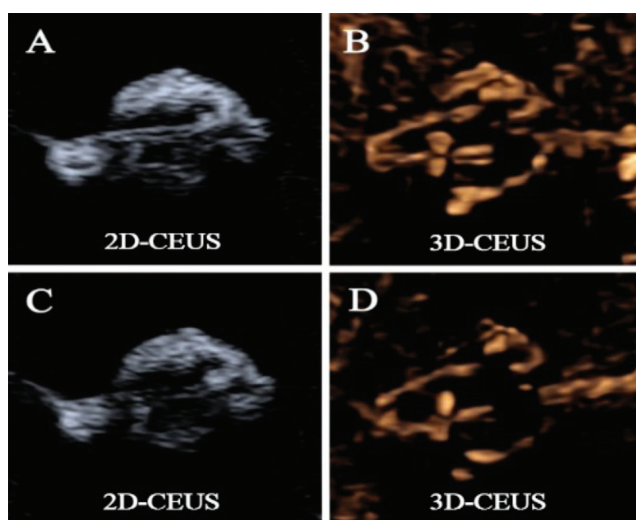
Two-dimensional contrast-enhanced ultrasound (2D-CEUS) and three-dimensional contrast-enhanced ultrasound (3D-CEUS) images of 32 cm perfusion model: A,B. Octafluoropropane-loaded cerasomal microbubbles (OC-MBs); C,D: SonoVue®
